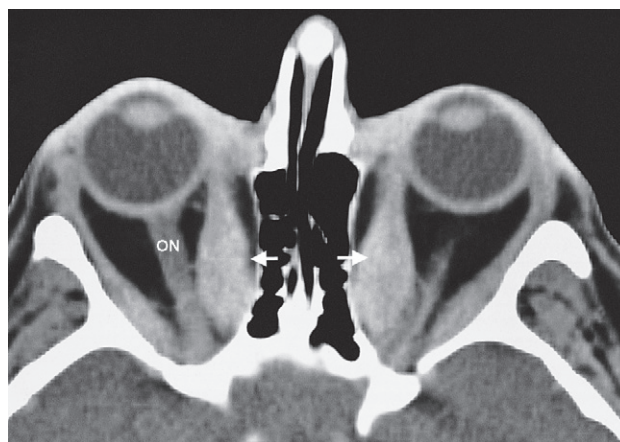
Thyroid eye disease. CT scan through the orbits showing enlargement of the extraocular muscles, particularly the medial rectus (arrows). ON; optic nerve.
